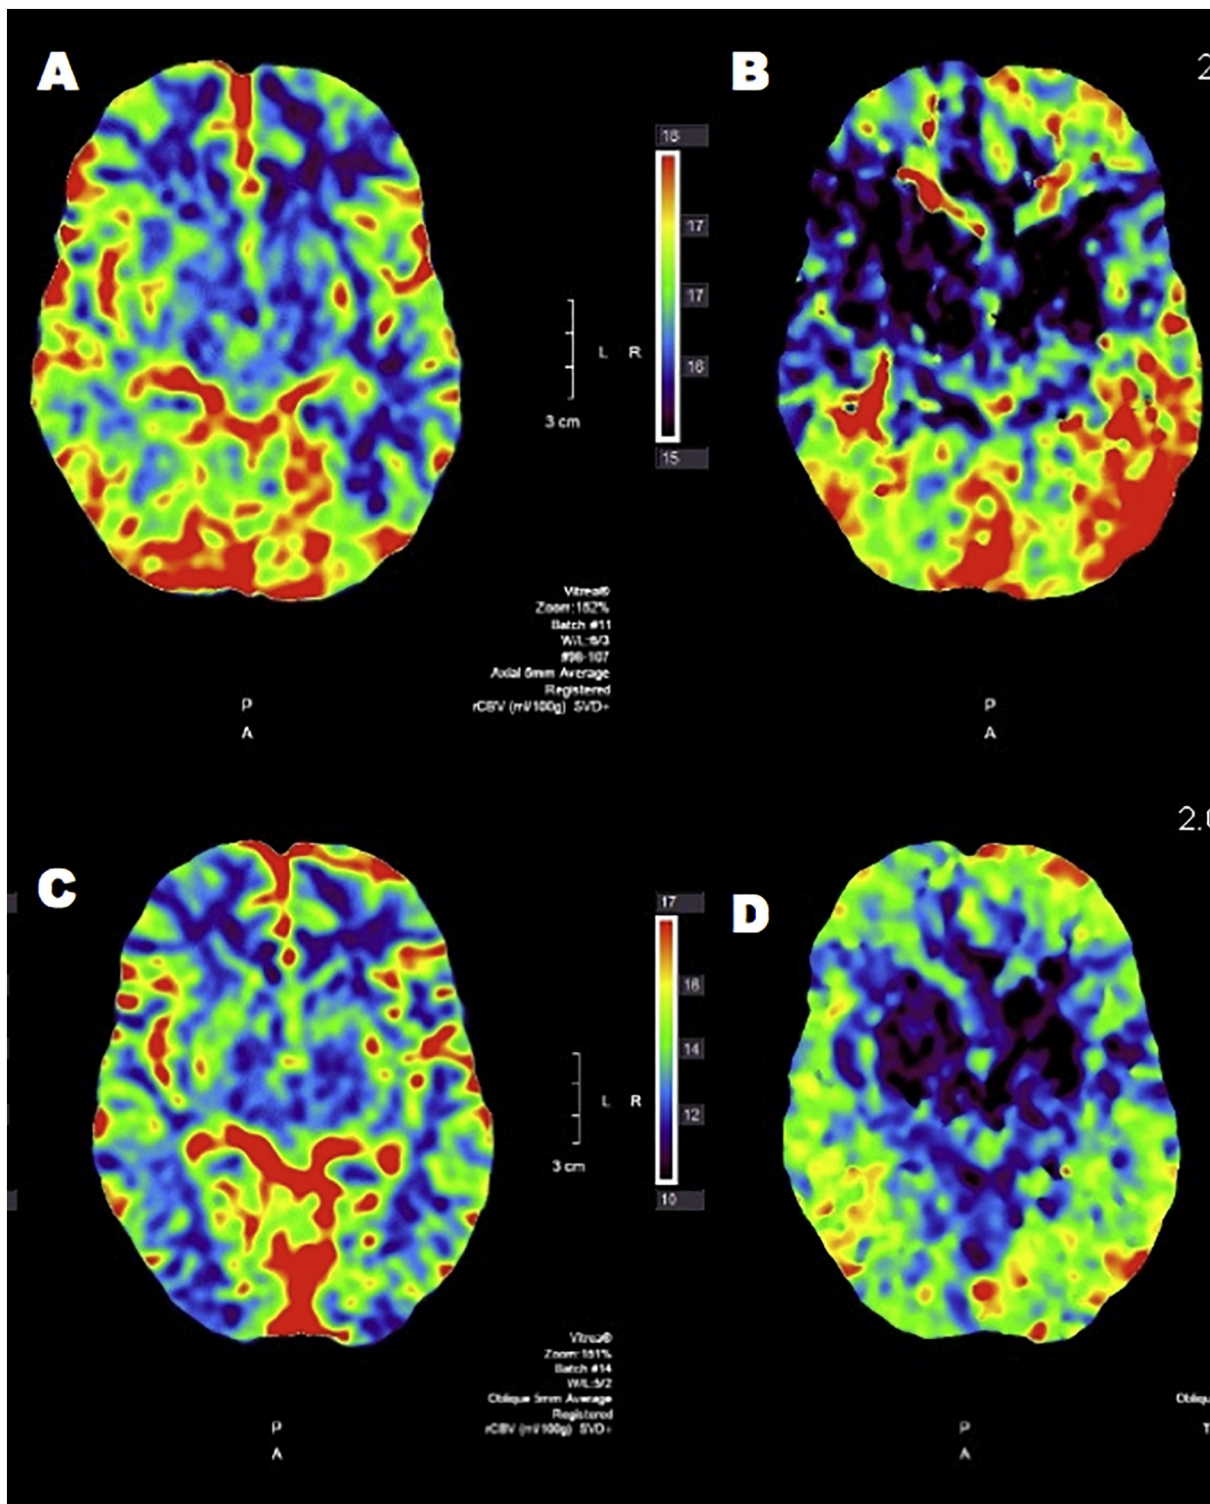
CT perfusion changes: Axial CT perfusion imaging reveals focal hypoperfusion in the left hemisphere in language areas (A: Cerebral Blood Volume, B: Mean Transit Time) performed 2 hours after the onset. 48 h after the first assessment, symptoms were absent and CT perfusion showed complete normalization of both parameters (C, D)
